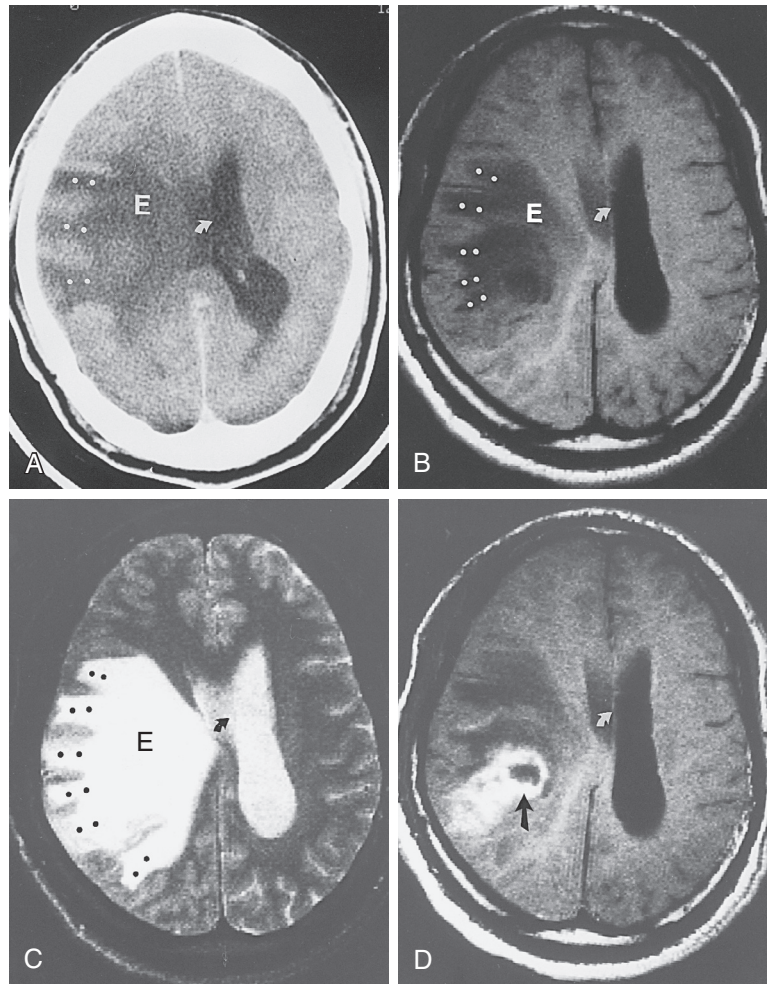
■ Vasogenic edema in glioblastoma. Non-contrast-enhanced axial computed tomography scan (A), axial T1-weighted magnetic resonance imaging (MRI) scan (B), and axial T2-weighted MRI scan (C) all demonstrate an area of edema (E). Edema extends along white matter fibers (dots), with normal gray matter interposed. Axial T1-weighted MRI scan following contrast enhancement (D) demonstrates the enhancing tumor nidus (arrow), distinct from surrounding edema. Subfalcine herniation is also demonstrated on these images by displacement of the falx (curved arrows).
